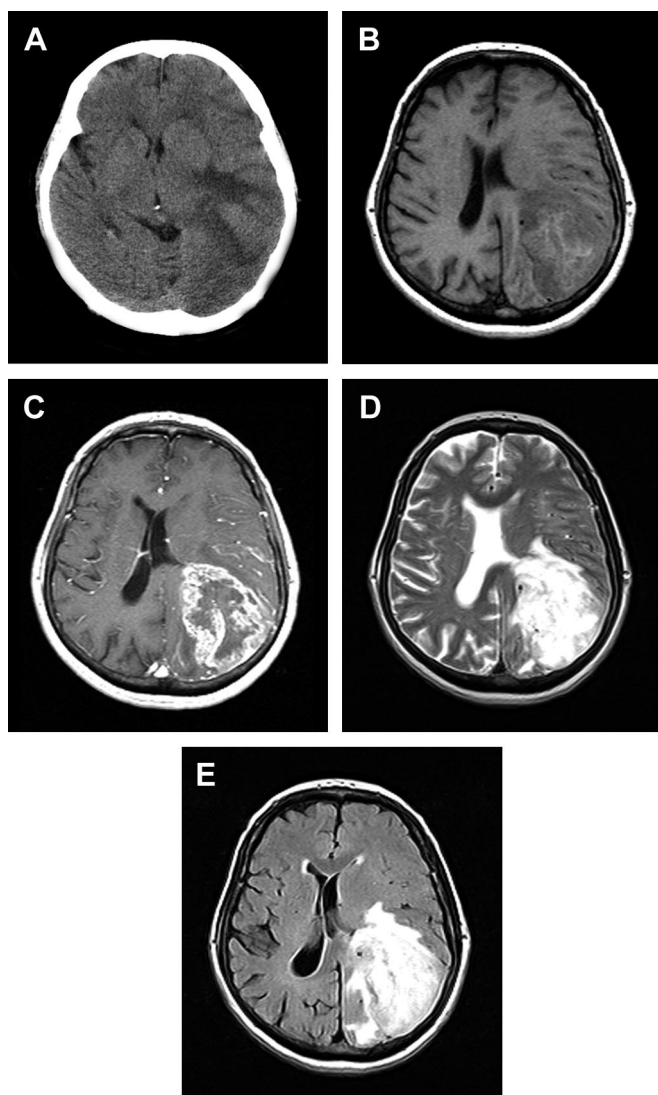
Imaging characteristics of brain edema (in this case caused by a tumor). CT scan (A) discloses edema spreading along white matter tracts. MRI T1-weighted sequence (B) shows an appearance similar to that of CT scan. T1-weighted sequence with gadolinium (C) highlights the contrast enhancement of the active tumor causing the edema. T2-weighted (D) and FLAIR (E) sequences better delineate edema in the form of bright signal.
